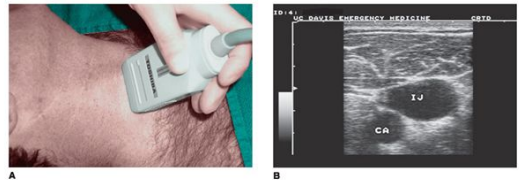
A: Probe position for ultrasound of the large internal jugular vein with deeper carotid artery and B: corresponding ultrasound image. CA, carotid artery; IJ, internal jugular vein.
